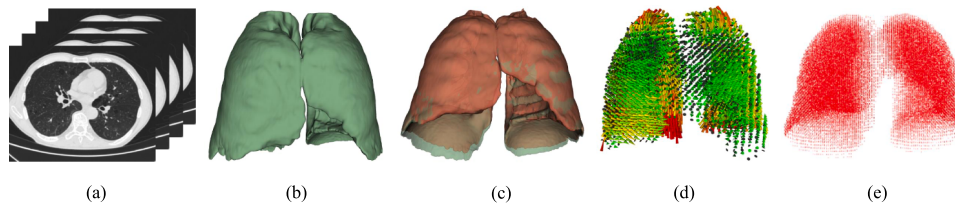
Lung data processing with the initial data collection plan. (a) Initial pulmonary CT images. (b) Lung 3D image after lung segmentation and reconstruction. (c) Overlapping of two lung 3D images from two phases of respiration, the end of inspiration and the small inspiration phase. (d) Lung-tissue displacements 1 represented by vectors. (e) Lung 3D image after down-sampling.
